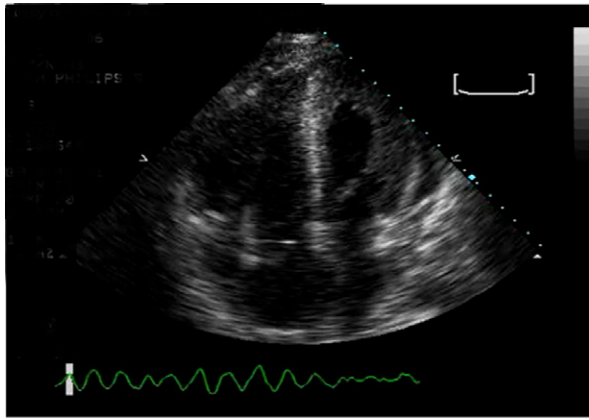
Transesophageal echocardiogram confirms ventricular fibrillation in a patient supported entirely by a continuous-flow left ventricular assist device.
